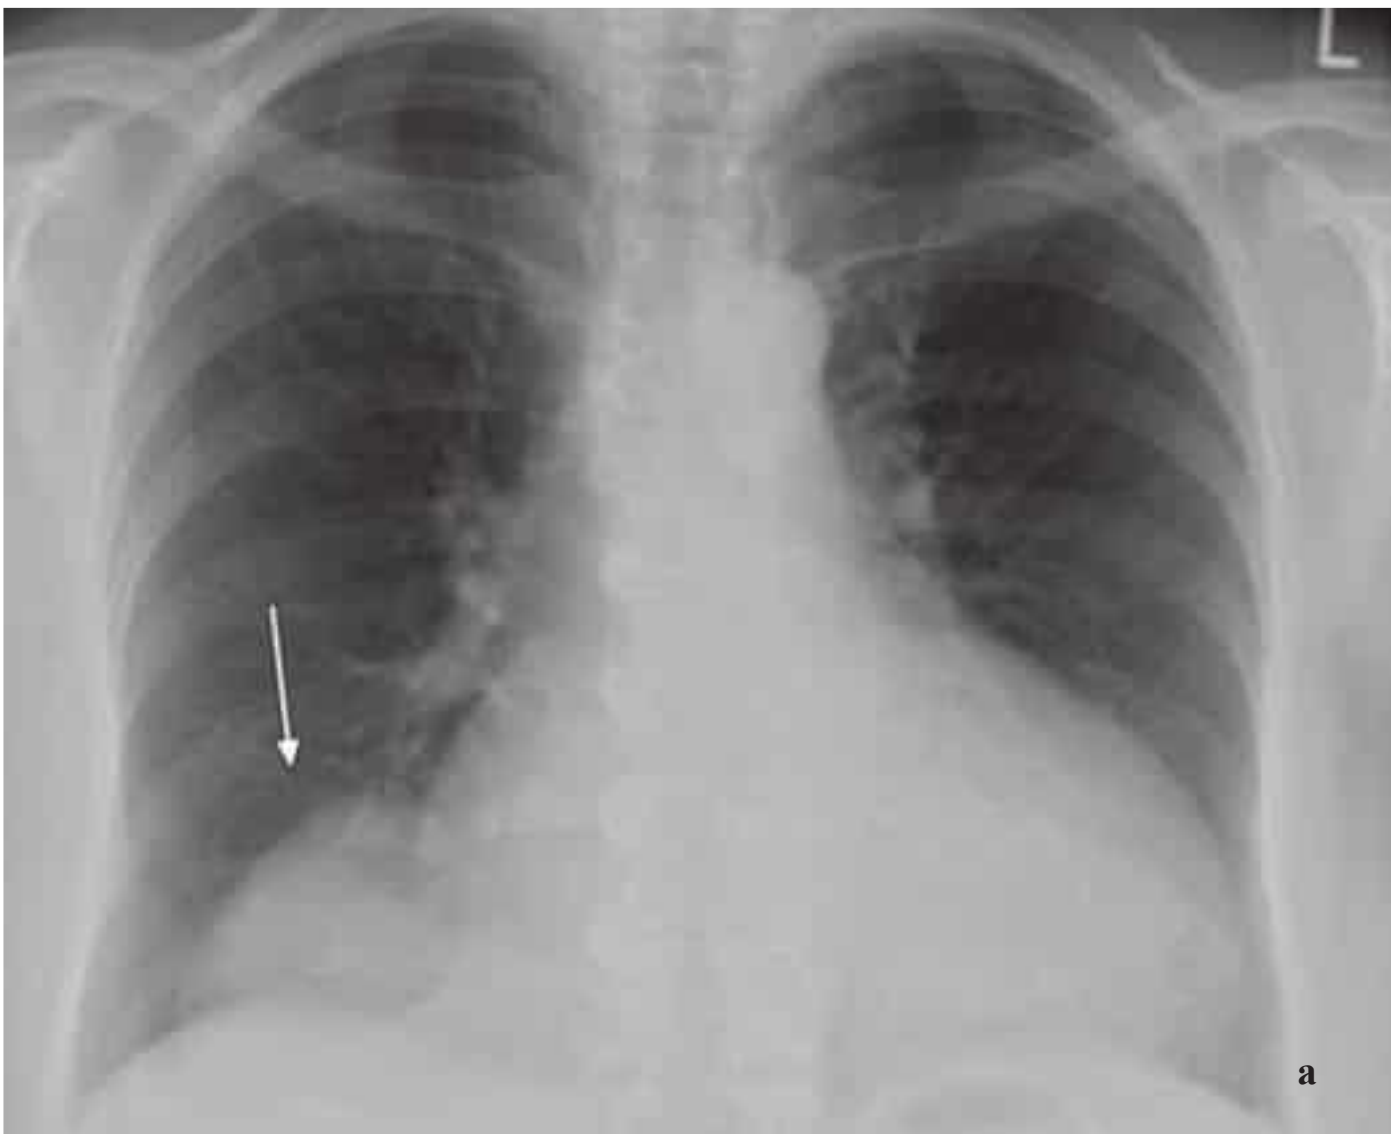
a, b Large pericardial cyst appears on the chest radiograph as a well-circumscribed mass projected over the right cardiophrenic angle (a). Contrast-enhanced CT (b) demonstrates the cystic mass (arrow) next to the right atrium.
